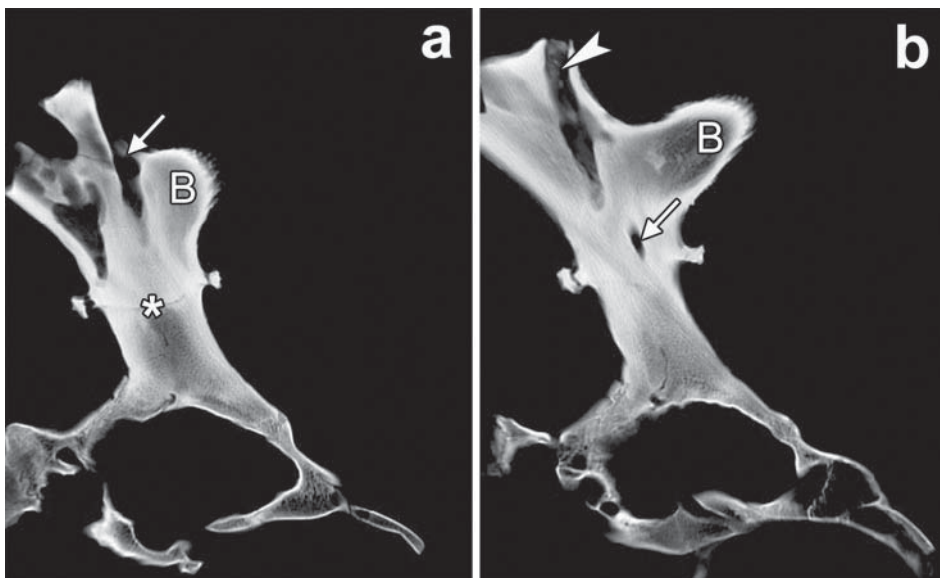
CT images (a, b) of the stump of the left antler showing parts of the cavitory system. Scan a is positioned medial to scan b. B - brow tine; asterisk - antler-pedicle junction; arrows - draining sinus opening in the furcation area between main beam and brow tine and its extension into the antler base; arrowhead - partly occluded draining sinus that opens immediately proximal to the fracture plane.
